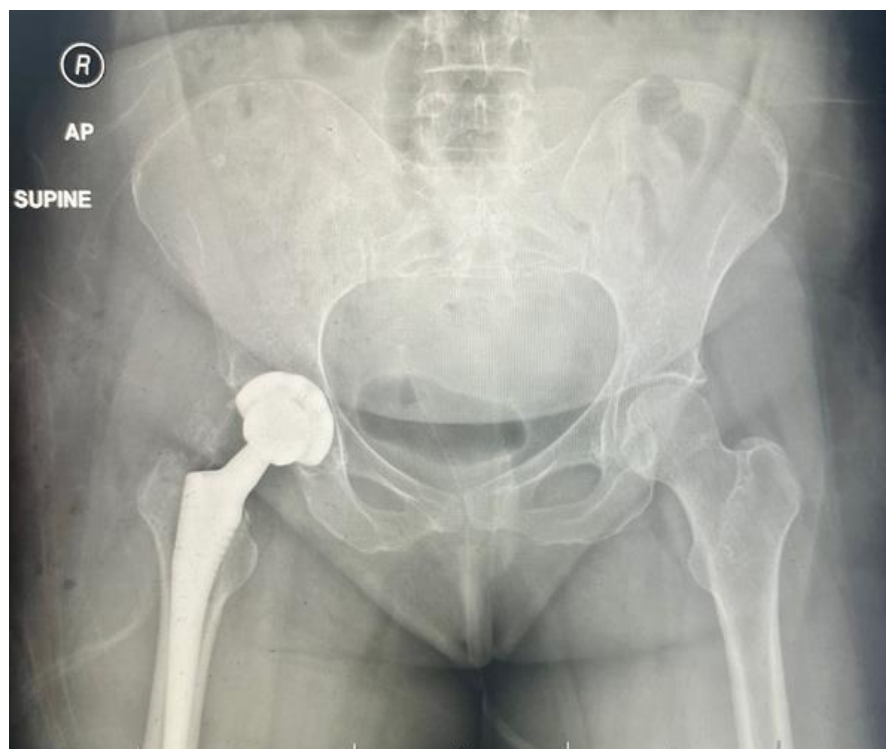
AP radiograph of the pelvis after the second surgery after procedure completion with implantation of the femoral stem.
